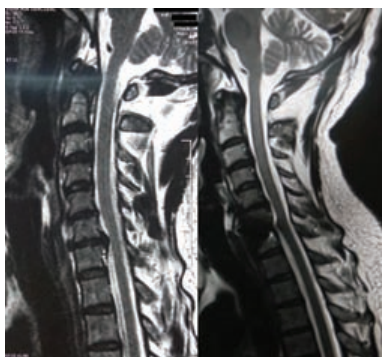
Case #1 MRI Pre Op (left) and Post Op (Right)
